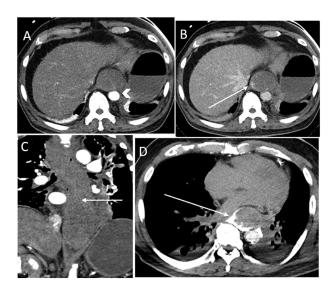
Axial (A) arterial and (B) portal venous (PV) phases of contrast enhanced CT reveals a linear streak of contrast in the distal esophageal wall on the arterial phase (arrow head) with subsequent pooling of contrast in the PV phase (arrow). Coronal reformatted image (C) shows a diffusely expanded esophagus by intramural hematoma and almost complete obliteration of the esophageal lumen (arrow).
